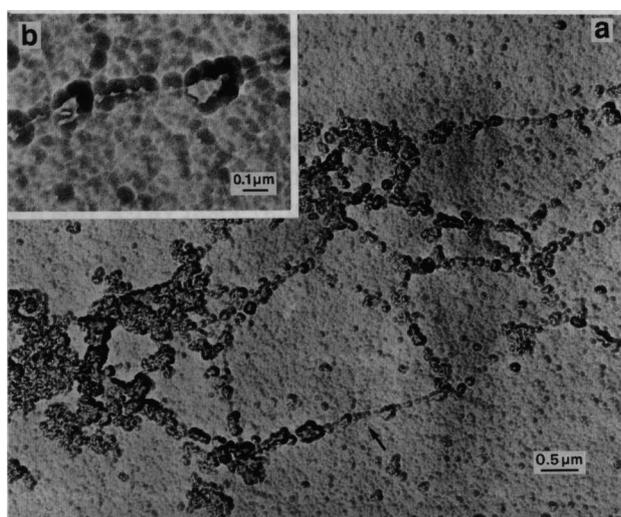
X-ray image of a stretched portion of a human chromosome [21]. An enlargement of the area indicated by an arrow in (a) is presented in (b).
